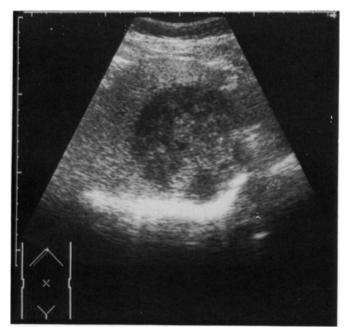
Sonography showed a space-occupying lesion.
